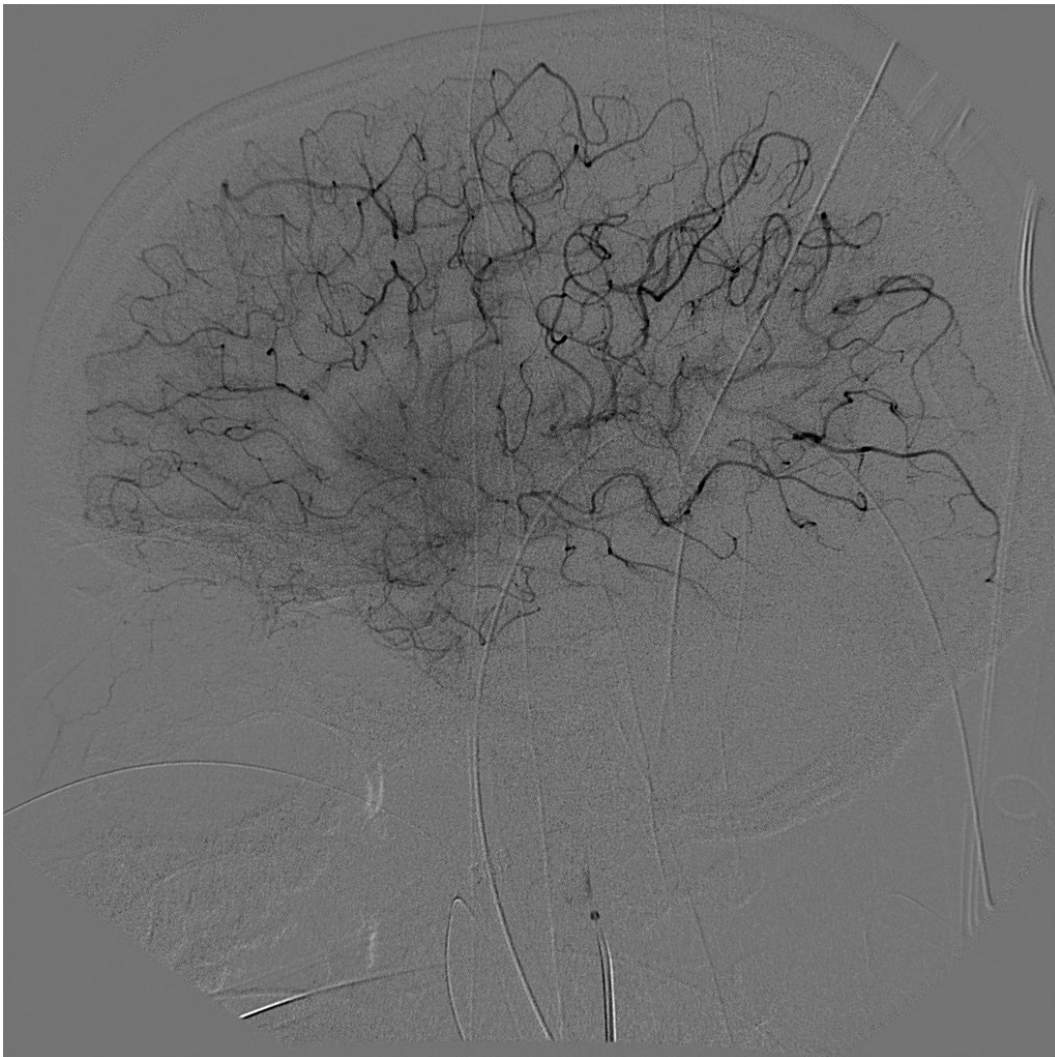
Angiographic Image: and X-ray image was acquired during contrast medium transit and the bone was subtracted leaving almost only the vascular tree.
